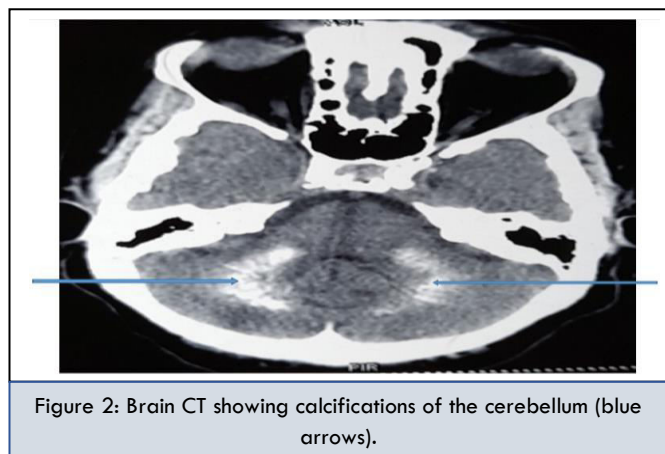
Brain CT showing calcifications of the cerebellum (blue arrows).
